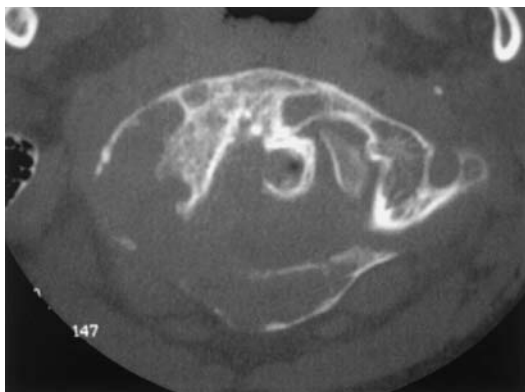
Axial CT scan of an ABC. The patient is a 7-year-old female with a 3-month history of neck pain and torticollis.
